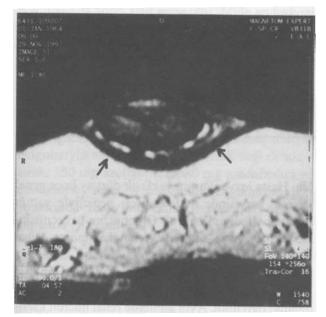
T1 weighed magnetic resonance imaging of the penis after intravenous contrast material injection. Note the filling defects due to thrombus in the lumen of superficial dorsal veins (white arrow).
